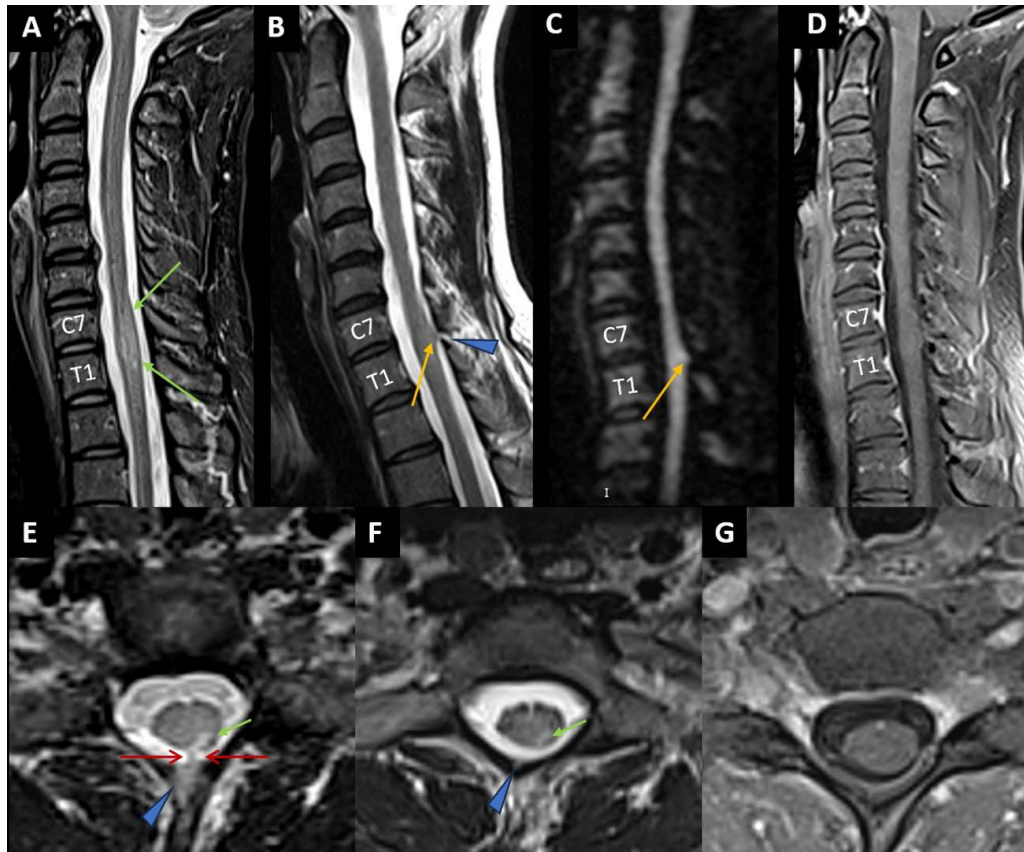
37-year-old female patient with limited dorsal myeloschisis. Cervical spine MRI on sagittal STIR (A), T2 (B), diffusion (C) and fat-saturated post-contrast T1 (D) weighted images; axial T2 (E-F) and fat-saturated post-contrast T1 (G) weighted images. There was a hyperintense eccentric expansile intramedullary lesion at C7-T1 (green arrows), with an exophytic and triangular shape of the left posterolateral aspect (orange arrows), extending toward the dura mater. Note is made for the focal tiny disruption of the posterior dura mater (blue triangles) and a fibrous tissue (rudimentary neural stalk – red arrows) connecting both. No abnormal enhancement was appreciated (D and G).
